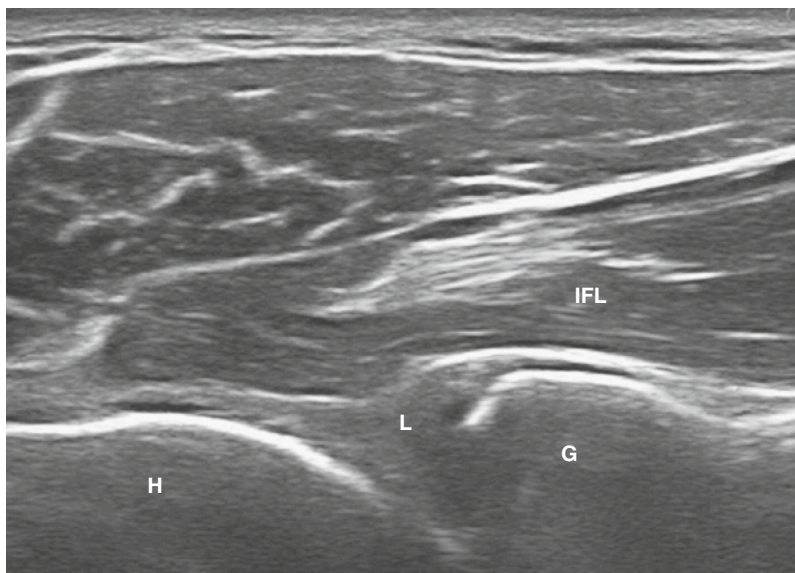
GLENOID LABRUM. Ultrasound shows the glenoid labrum. G, glenoid; H, humeral head; INF, infraspinatus tendon; L, glenoid labrum.
